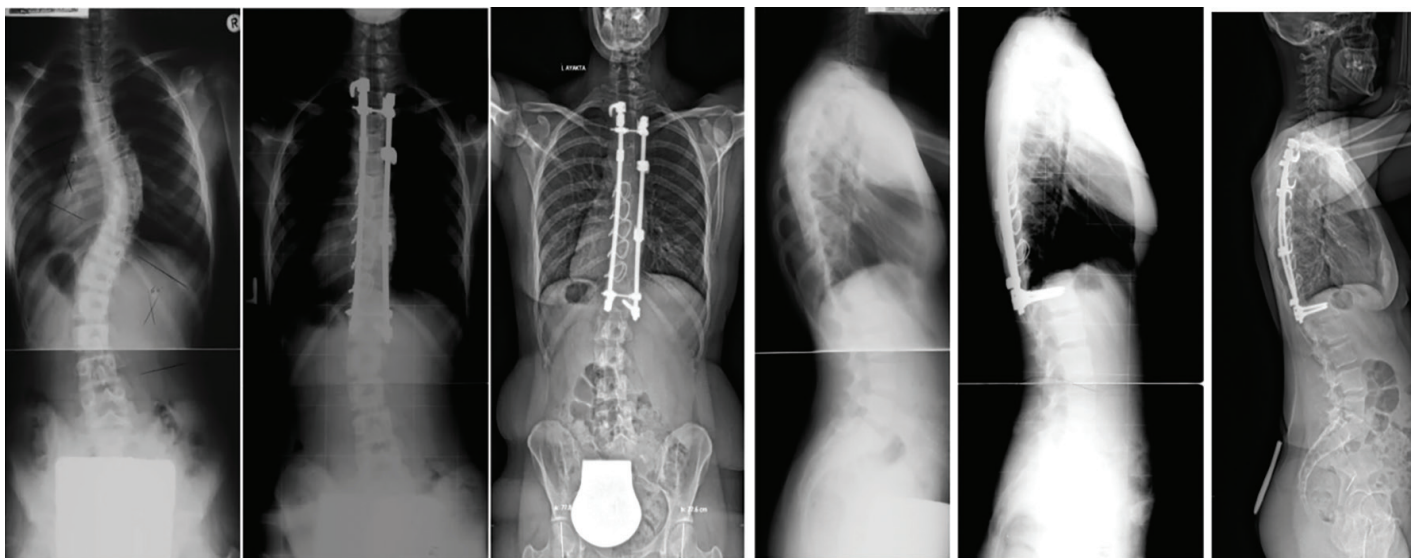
Standing whole-spine anteroposterior and lateral radiographs of a 12-year-old girl treated with posterior hook-screw instrumentation for adolescent idiopathic scoliosis. At 29-year follow-up, coronal and sagittal alignment remain well balanced with maintained deformity correction
